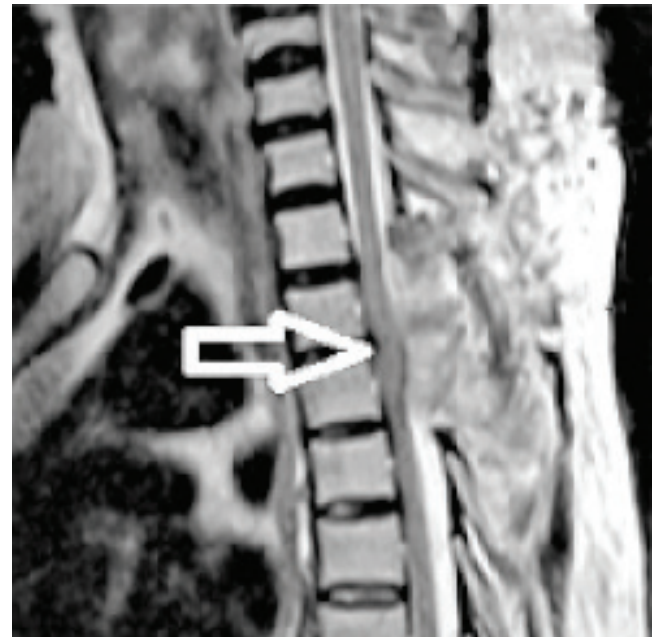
T2-W sagittal MR images (Post-operative)
